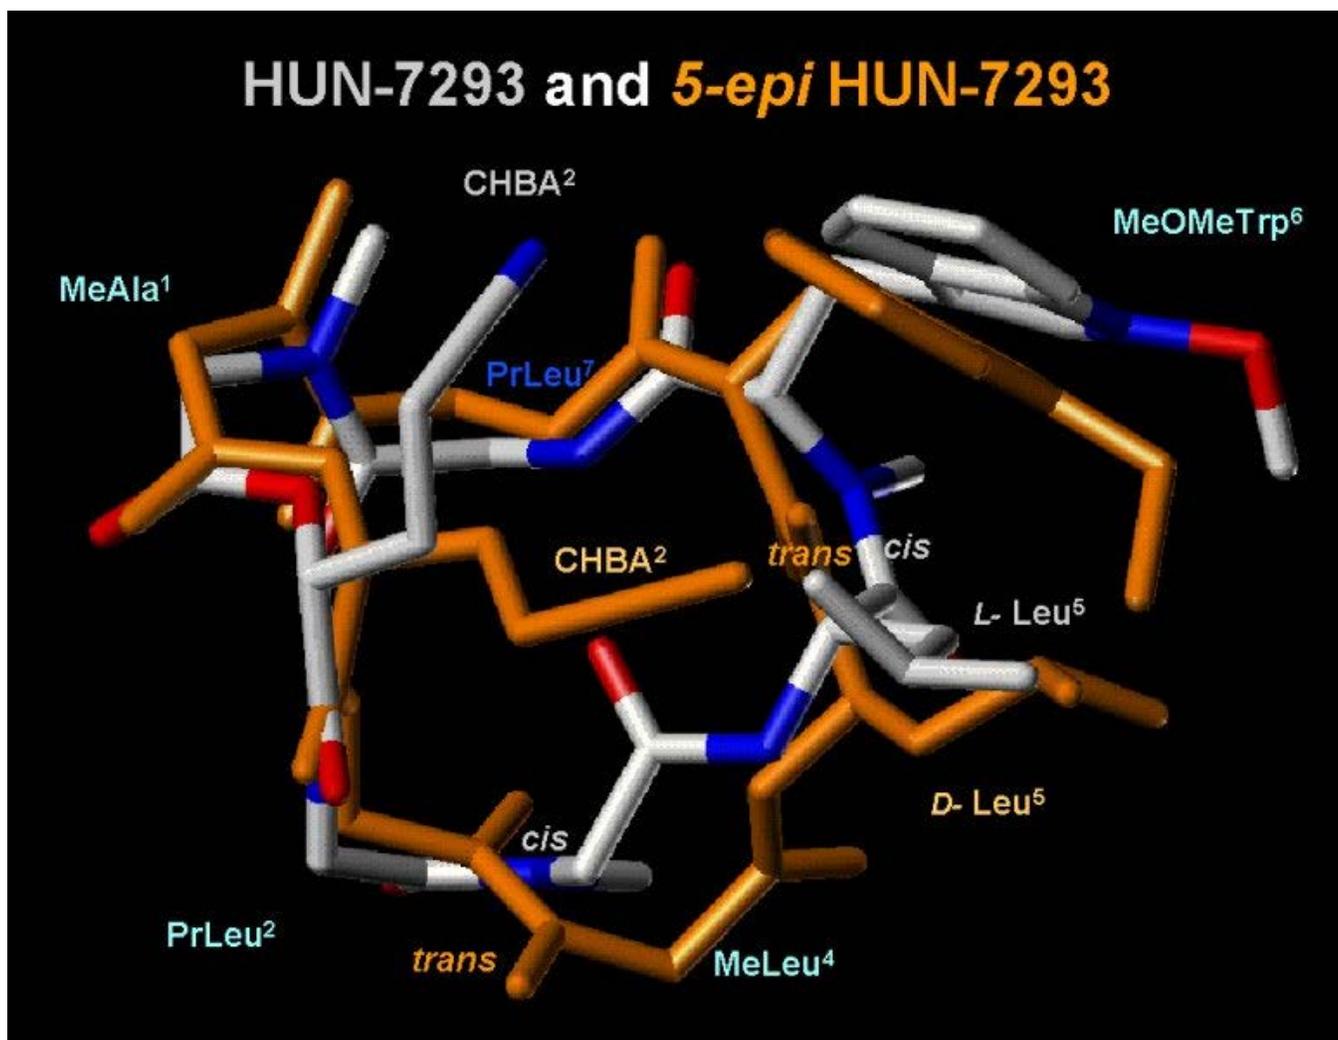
Overlay of the natural product HUN-7293 (X-ray structure, grey) and its Leu⁵-epimer (NMR structure, orange; 3D: [msv-file](#) or [mol-file](#))
